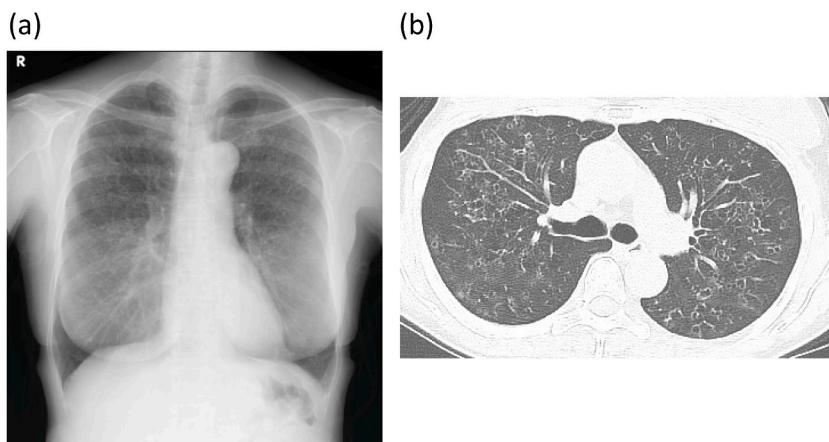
Radiological findings on admission. (a) Chest radiograph shows granular shadows predominantly in the upper and middle fields of both lungs. (b) Chest high-resolution computed tomography shows multiple cystic lesions with thick walls and nodular shadows predominantly in the upper lobe. Some cystic lesions are irregular in shape.
